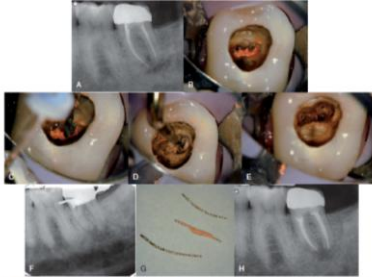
Mesial caries restoration. A, Preoperative radiograph. B, Mesial caries exposed by careful excavation of glass-ionomer. C, Use of the brush to heat the caries and soften the glass ionomer. This allowed removal of all of the caries using modified bright-light therapy. The other could not be removed using heat or solvent. D, Elongation of the crown to facilitate opening. E, Caries removed and condensed with a radiograph. F, Mesial caries showing glass ionomer still adhering to them. G, Final obturation of the tooth.
